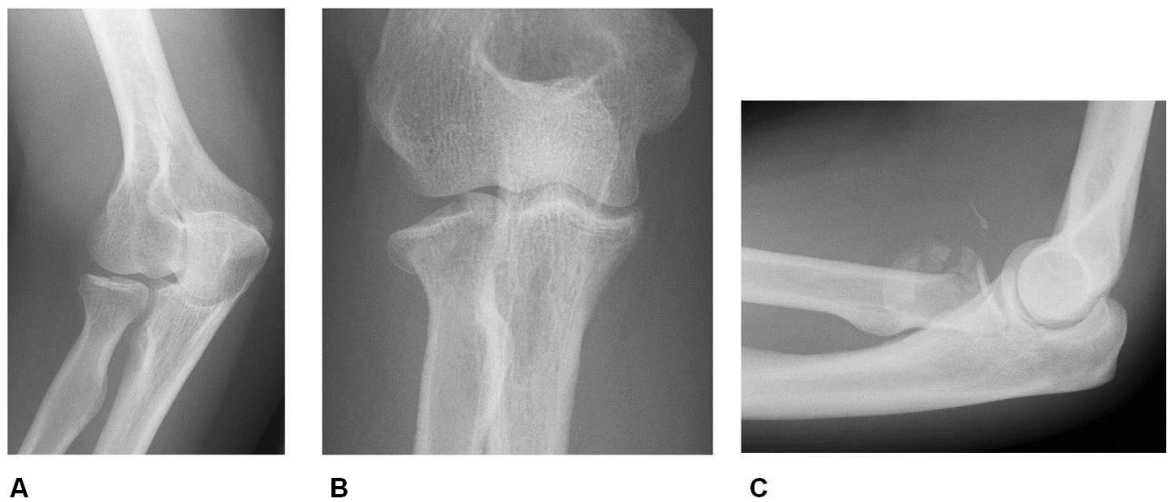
Radiographic examples of a Mason type 1 (A; AP view), type 2 (B; AP view) and type 3 (C; lateral view) fractures.
